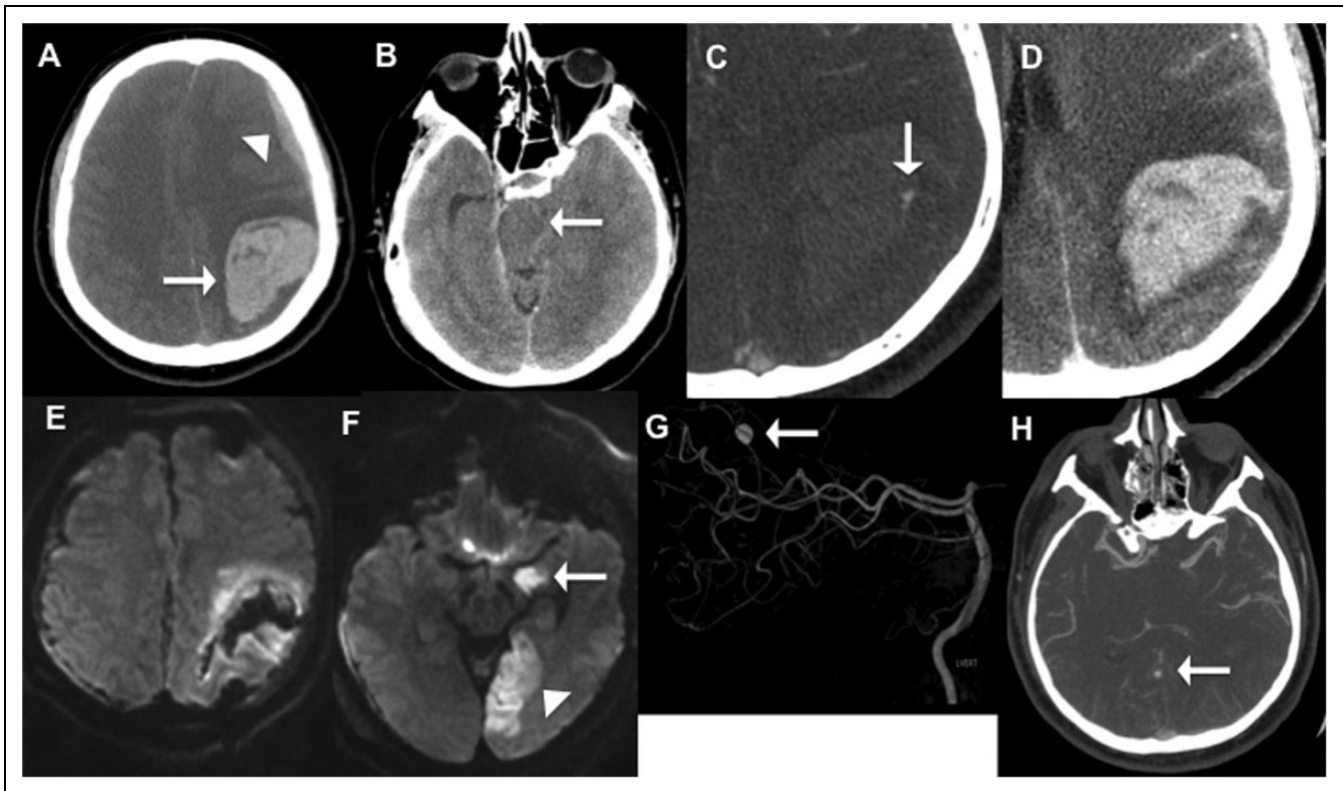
Brain and vessel imaging. Axial noncontrast head computed tomography (CT) on admission with a large left parietal intraparenchymal hemorrhage (arrow) and left frontal subdural hematoma (arrowhead; Panel A) with developing left to right midline shift and left uncus herniation (Panel B). CT angiogram, arterial phase with a focus of hyperattenuation (arrow) within the lateral margin of the hemorrhage concerning for a distal infectious aneurysm (Panel C). Postcontrast scan showed no extravasation of contrast in this same area seen as hyperattenuated on the computed tomography angiogram (CTA) arterial phase, suggesting the contrast was in a vascular structure (Panel D). MRI brain diffusion images demonstrating the evolving left parietal hematoma after evacuation (Panel E), and consequences of herniation: infarcts of the left uncus (arrow) and left posterior cerebral artery distribution (arrowhead; Panel F). Subsequent catheter angiogram with a left vertebral injection confirms a distal right posterior cerebral artery 4.8×5.6 mm aneurysm (Panel G), which in retrospect was seen on the admission CTA (arrow; Panel H).
